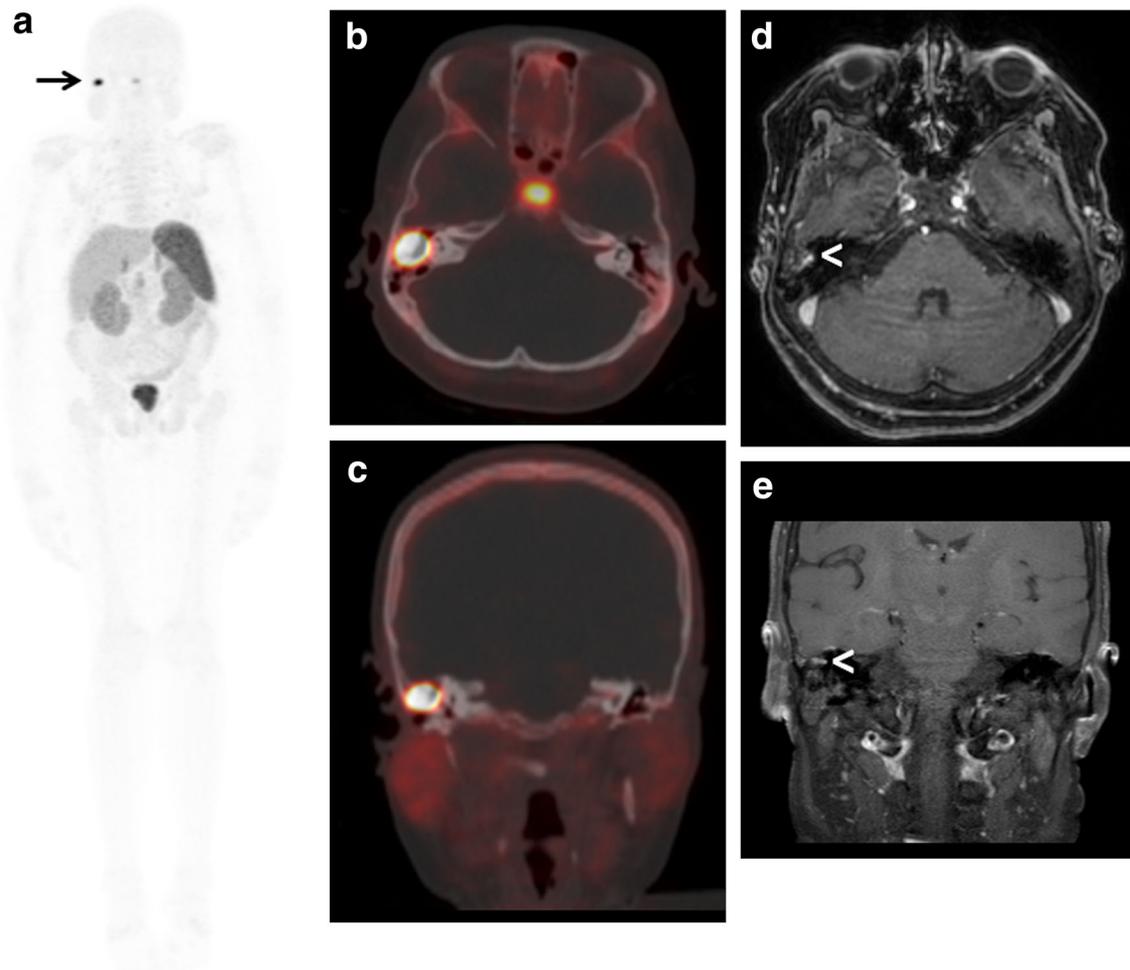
A 44-year-old female with a few years of history of hypophosphatemic osteomalacia (HO) suspected to be caused by an unknown primary tumor—tumor-induced osteomalacia (TIO)—that had not been detected by other imaging studies was scanned with ^{68}Ga -DOTATATE whole-body positron emission tomography/computed tomography (PET/CT) in an attempt to localize the lesion. The ^{68}Ga -DOTATATE PET coronal maximum-intensity-projection (MIP) image
